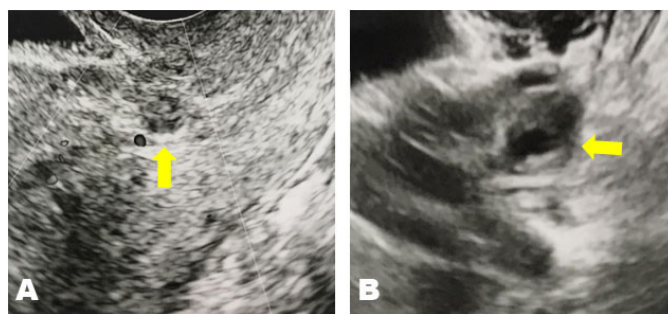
Transvaginal Doppler ultrasonography images. (A) A 10-mm-large cystic structure without a yolk sac and blood flow adjacent to the scar of the uterus. (B) A 16-mm-large low echo area is accompanied by a white ring in the left adnexa.
